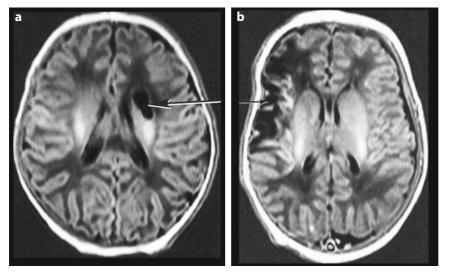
Early brain MRI showing examples of middle cerebral artery infarcts involving the lenticulostriate branch (a) and the main branch (b)
